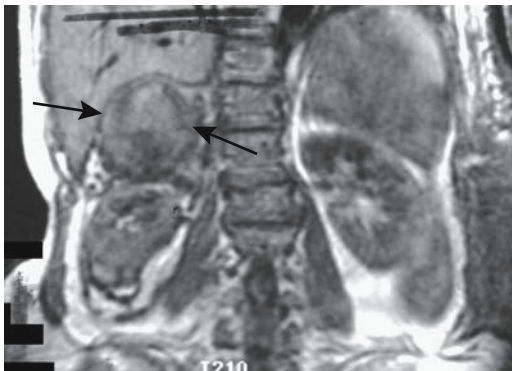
Bleeding pheochromocytoma (arrows) identified on T1-weighted coronal image. Hypointensity surrounding the right kidney represents a perinephric and paranephric hematoma. (Source: Burgener FA, Meyers SP, Tan RK, Zaunbauer W. *Differential Diagnosis in Magnetic Resonance Imaging*. Stuttgart: Thieme, 2002, with permission.)
